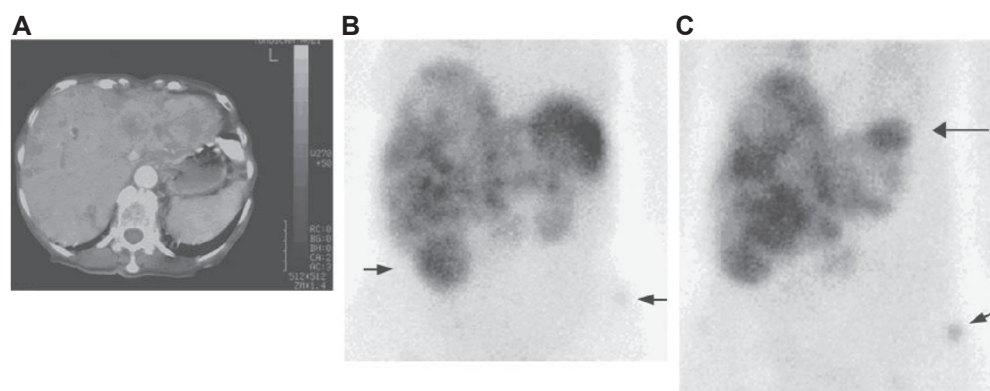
CT (A), ¹¹¹In-pentetreotide (B), and ¹²³I-MIBG (C) images of a patient with advanced functioning EC cell carcinoid show multiple metastases to the liver with intense uptake of both tracers. An additional site of uptake (B, left arrow) represents the right kidney. MIBG scan visualizes a hepatic lesion (C, upper arrow) which is obscured by physiologic splenic uptake on pentetreotide imaging. An osseous metastasis in the left pelvic bone (B and C, arrows to lower right) is also better visualized in the MIBG scan. Copyright © 2006. Reprinted by permission of the Society of Nuclear Medicine from Ezziddin S, Logvinski T, Yong-Hing C, et al. Factors predicting tracer uptake in somatostatin receptor and MIBG scintigraphy of metastatic gastroenteropancreatic neuroendocrine tumors. *J Nucl Med.* 2006; 47(2):223–233.
